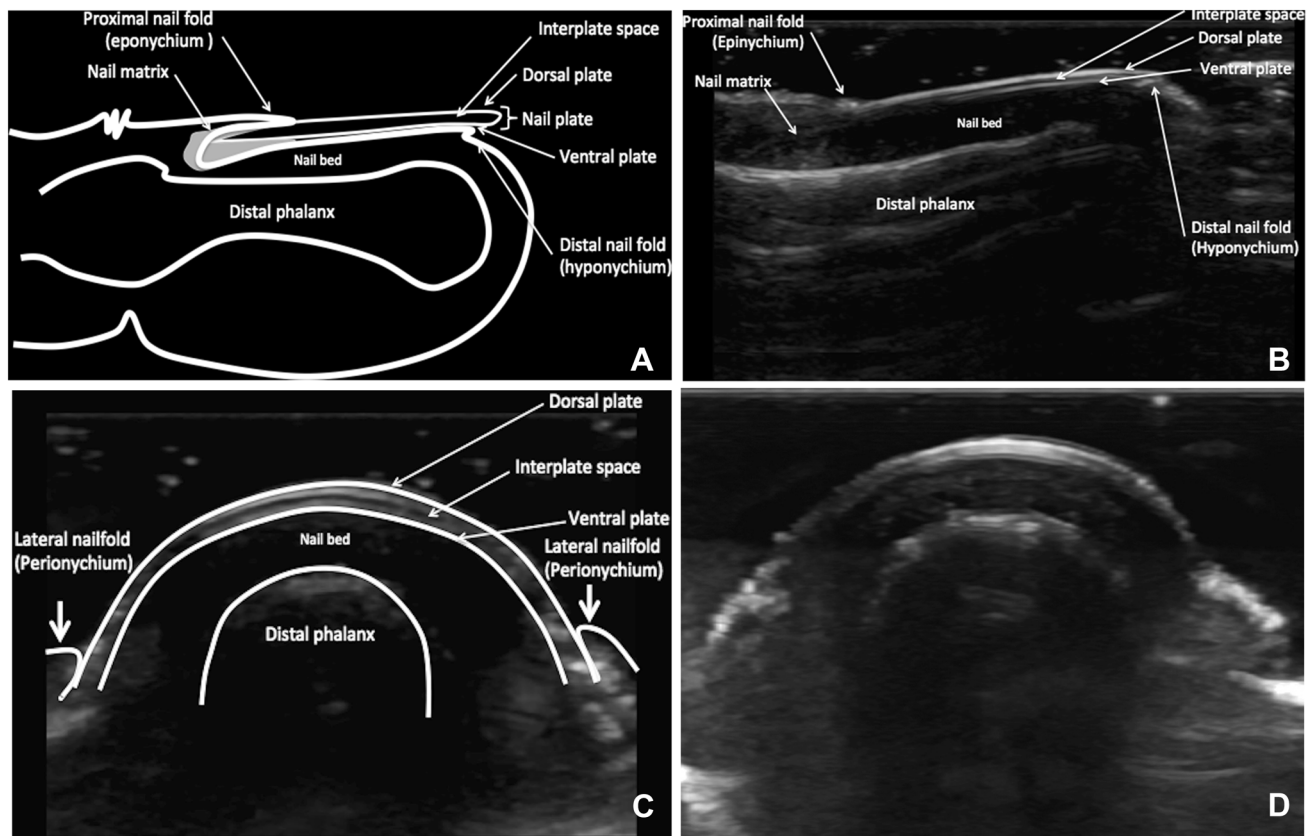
a Anatomic scheme of a longitudinal view of the nail. b Ultrasound, longitudinal view. Anatomic components of the nail unit and periungual zone are pointed out. c Anatomic scheme of a
